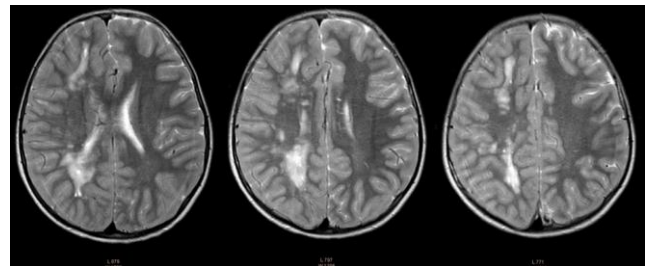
T2-weighted TSE (Turbo Spin Echo) images, unenhanced brain MRI
